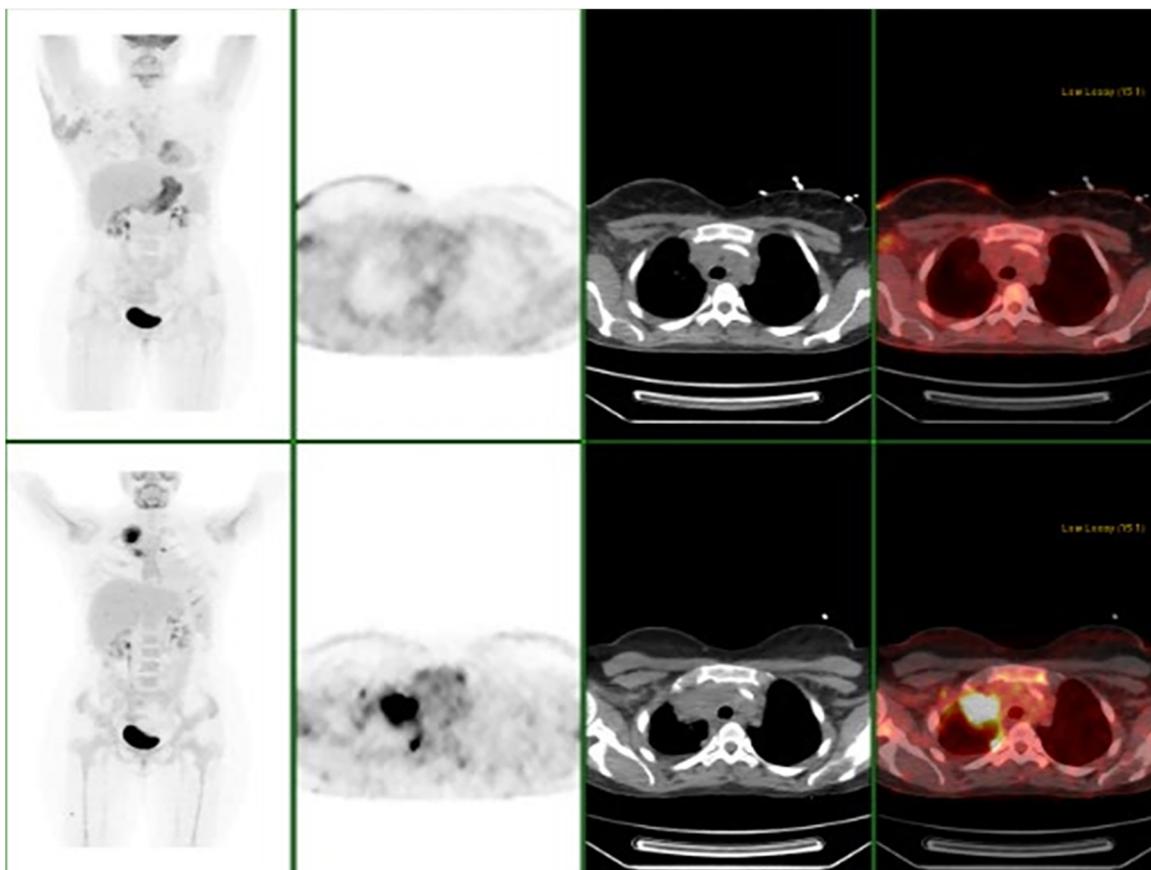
Positron emission tomography/computed tomography (PET/CT) scan prior to and following nivolumab therapy in primary mediastinal B-cell lymphoma. The lower panel demonstrates the scan prior to initiation of nivolumab and the upper panel following 8 cycles of therapy demonstrating complete metabolic response.
